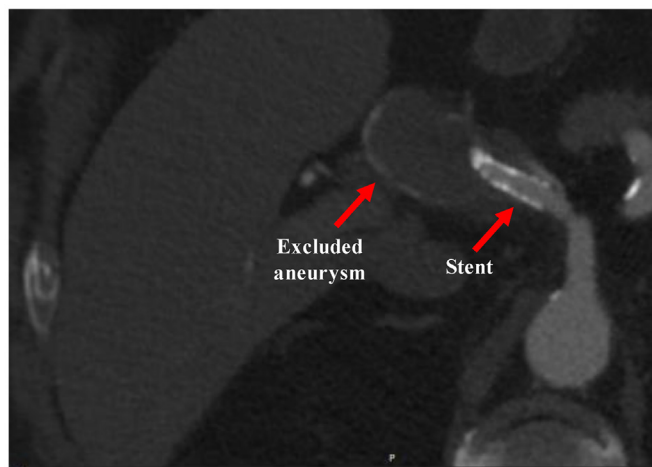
Computed tomography angiography in the axial view at 30 days after the procedure demonstrating patent right hepatic artery (RHA) stents.
